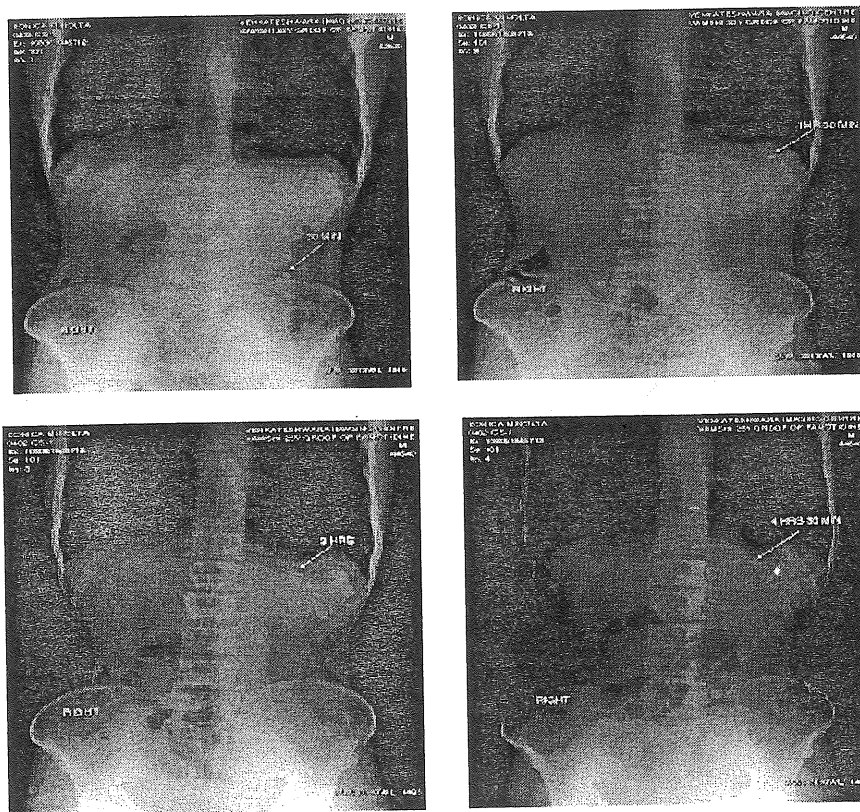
Representative of radiographic images showing the presence of BaSO₄-loaded floating tablet in the stomach at different time periods in fed state (The tablet is pointed by an arrow).
